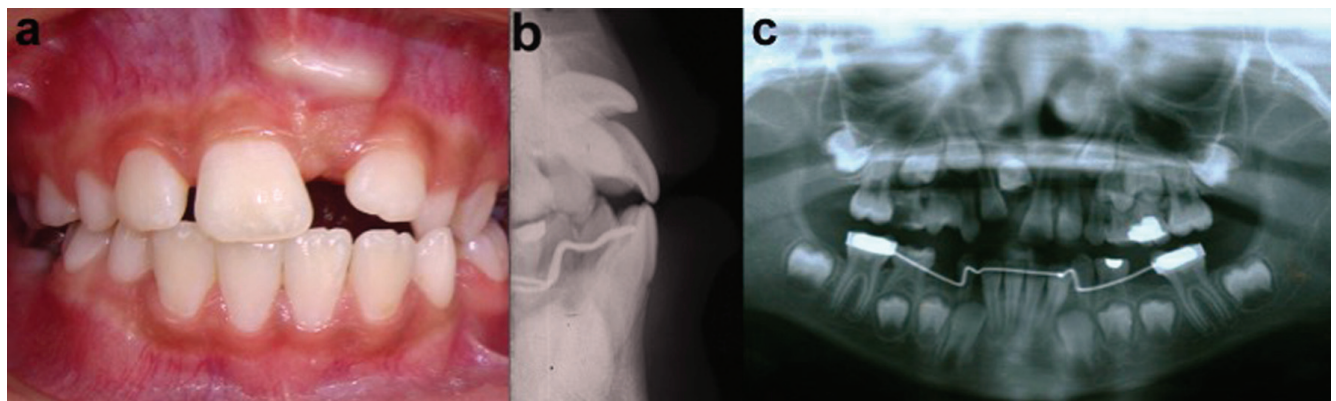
a) Initial aspect of tooth in a horizontal position at the level of the labial sulcus and lack of space. b) Lateral radiograph: impaction of permanent maxillary left central incisor. c) Orthopantographic radiograph: impaction of permanent maxillary left central incisor (ectopic position).
